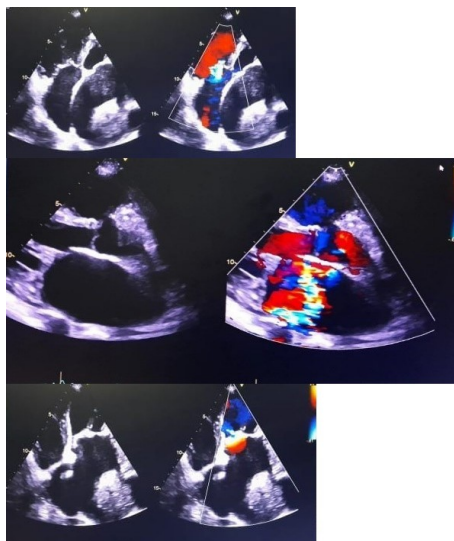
Echocardiography show Mitral stenosis in RHD
